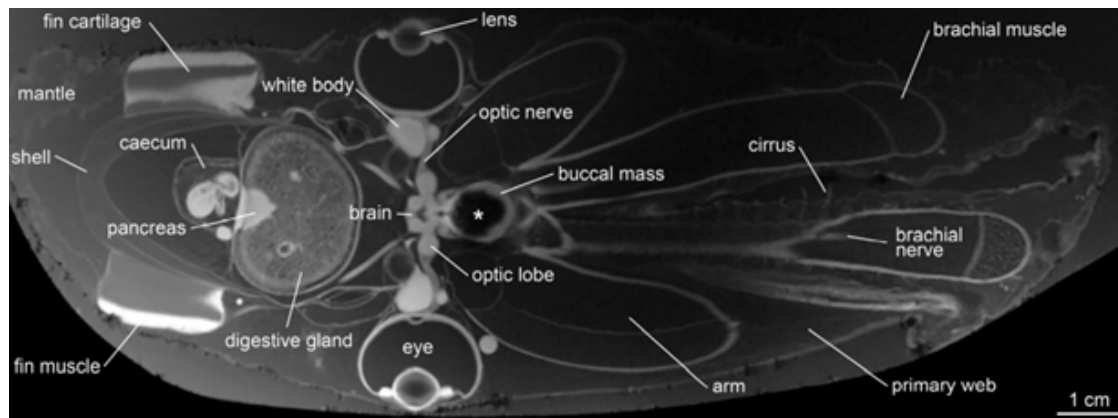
Virtual section of *Emperor dumbo octopus* through the 3D MRI dataset with anterior facing right. (Credit: Ziegler and Sagorny, *BMC Biology*, 2021) [2]
